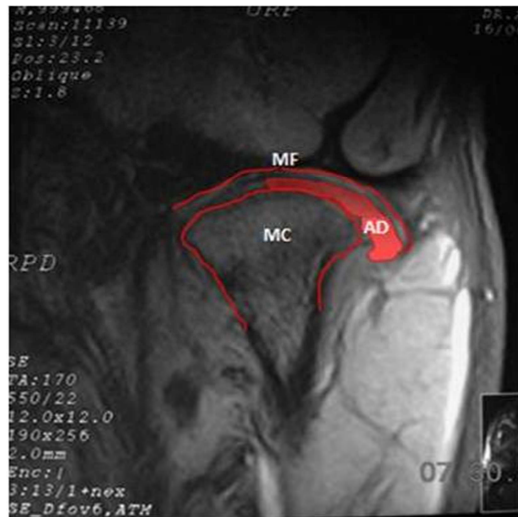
MRI in Oblique Planar Coronal Section on which the Following Structures are Recognized: Mandibular Fossa (MF), Mandibular Condyle (MC) and Articular Disc (AD)
